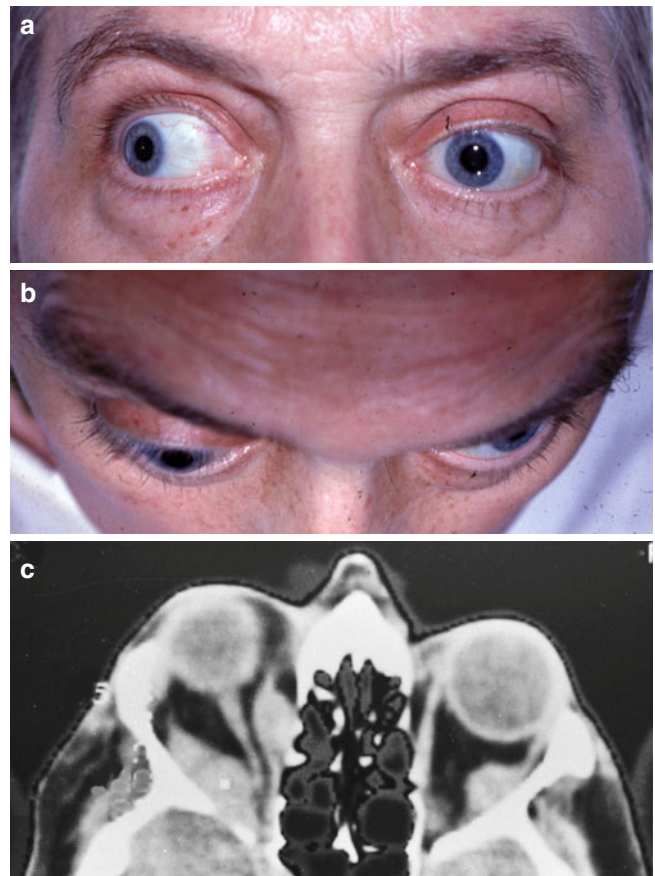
Orbital metastasis. (a) Atypical optomotor function; (b) exophthalmos, best seen from above; (c) CT scan of orbital metastases
